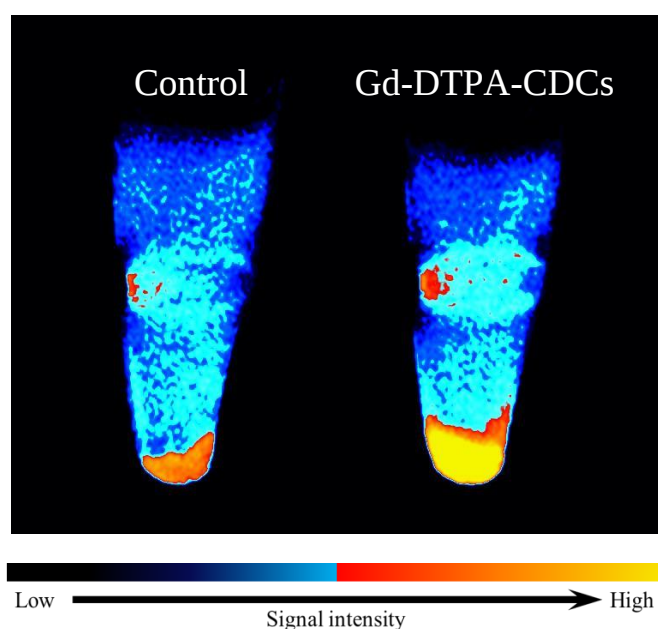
CDCs were labelled with Gd-DTPA using calcium-phosphate precipitation. Labelled cells were pelleted at the bottom of a 1.5 ml eppendorf tube and topped with 2% agarose in DMEM/F12 medium. Representative T1-weighted MR images showed that Gd-DTPA-CDCs produced higher signal than the unlabelled CDCs (control) (n=2).
